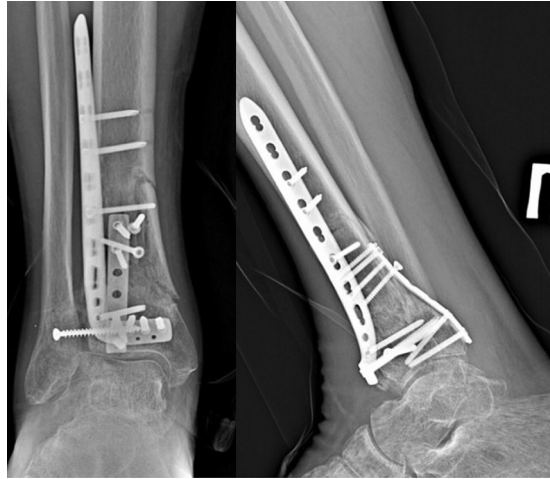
Radiographs at a 6-month follow-up
